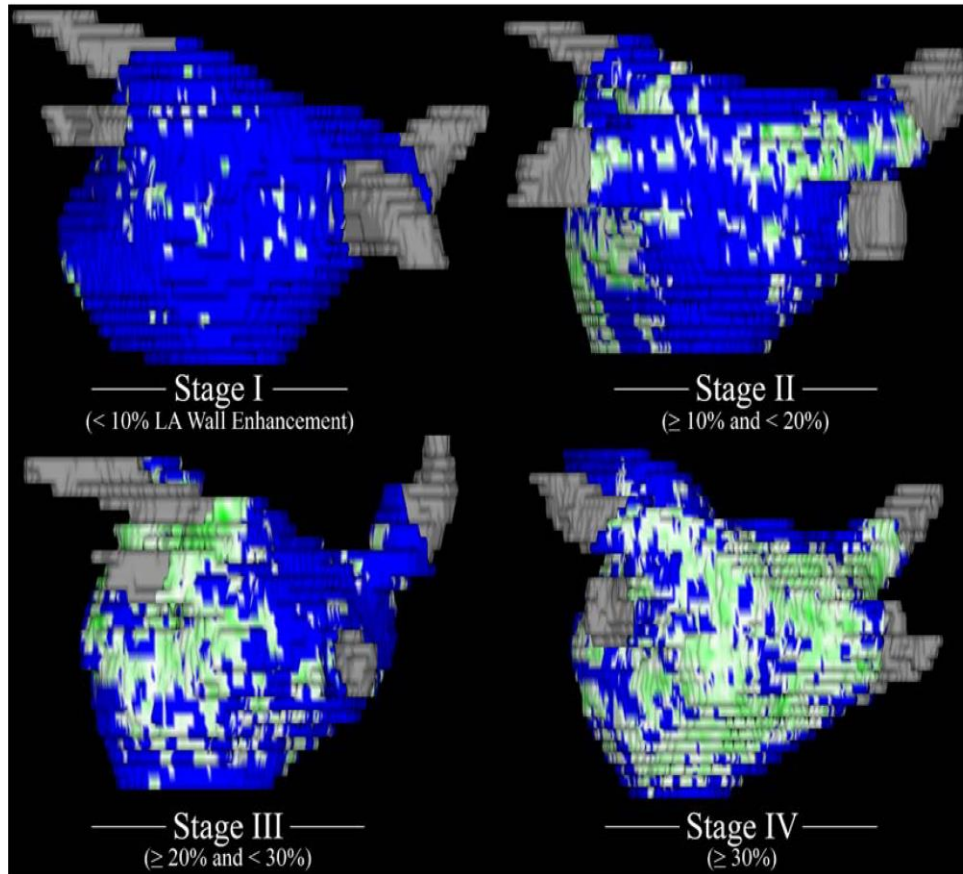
Four stages of left atrial (LA) structural remodeling (SRM) based on 3-dimensional late gadolinium enhancement MRI scans. Representative examples from patients in each stage of LA remodeling in posterior-anterior views (above examples of stages I-IV are 3%, 13%, 26%, and 56%, respectively). Normal LA wall is displayed in blue with SRM changes in green. The pulmonary veins are shown in gray.
